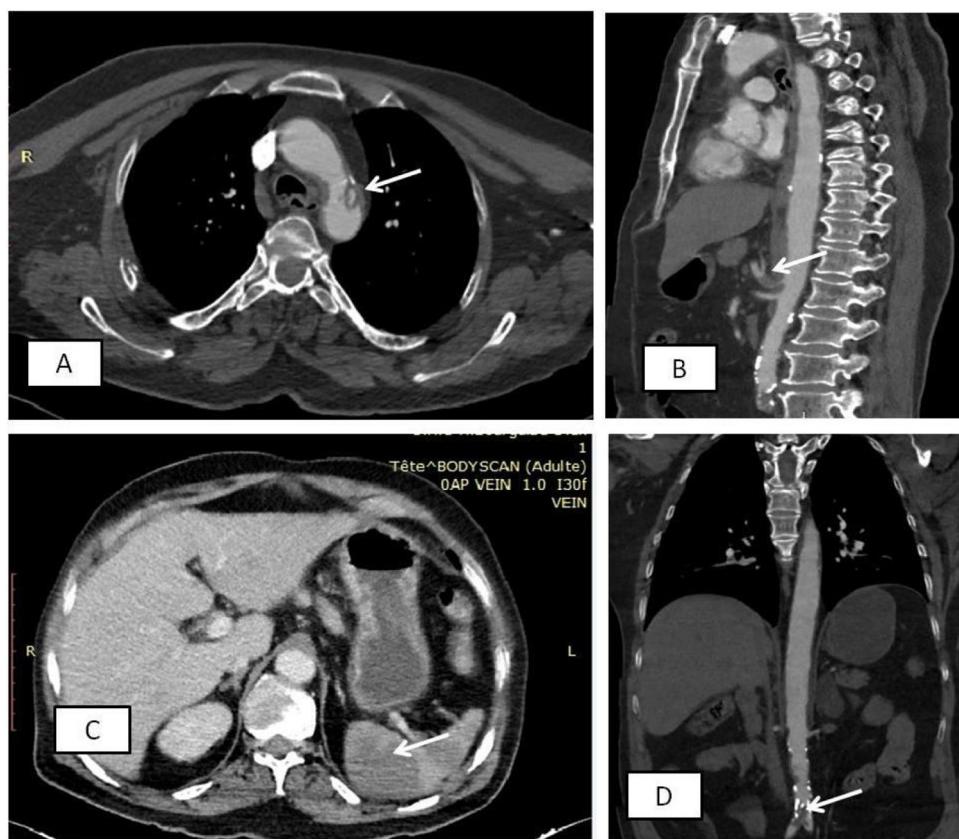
The computed tomography body scan performed on admission showed an unstable atheromatous calcium plaque of the aortic isthmus measuring 7 mm in maximum thickness and extending over 18 mm of irregular contours (arrow image A). It showed again an extensive endoluminal defect of 14 mm at the level of the emergence of the celiac trunk (arrow image B), foci of splenic infarction during the portal venous phase (arrow image C), unstable sub-occlusive plaque of the abdominal aorta up stream of its bifurcation extended over 19 mm and 8 mm thick (arrow image D).
